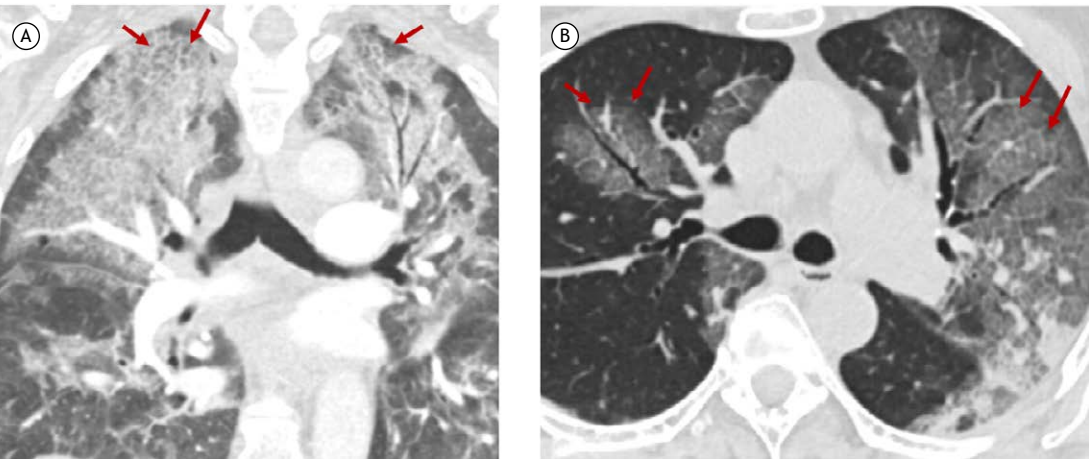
In A, a coronal CT scan with lung window settings of a male patient with respiratory infection with *Pneumocystis carinii*, showing bilateral areas of crazy paving in the upper lobes, sparing the subpleural regions (arrows). In B, an axial CT scan of a male patient with SARS-CoV-2 infection, demonstrating several areas of ground-glass attenuation with superimposed interlobular septal thickening, corresponding to the crazy-paving pattern (arrows).
